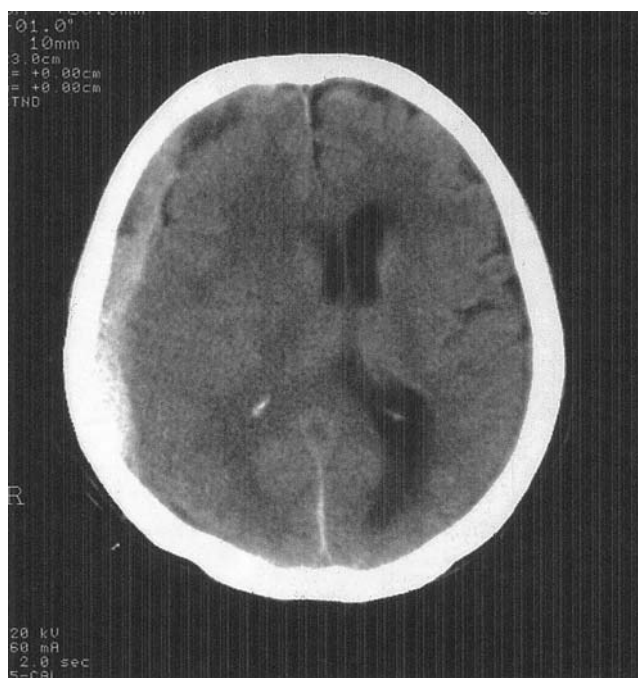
Patient #2. Brain computed tomography scan showing subdural hematoma in the right convexity space with a leftward shift of the midline.
